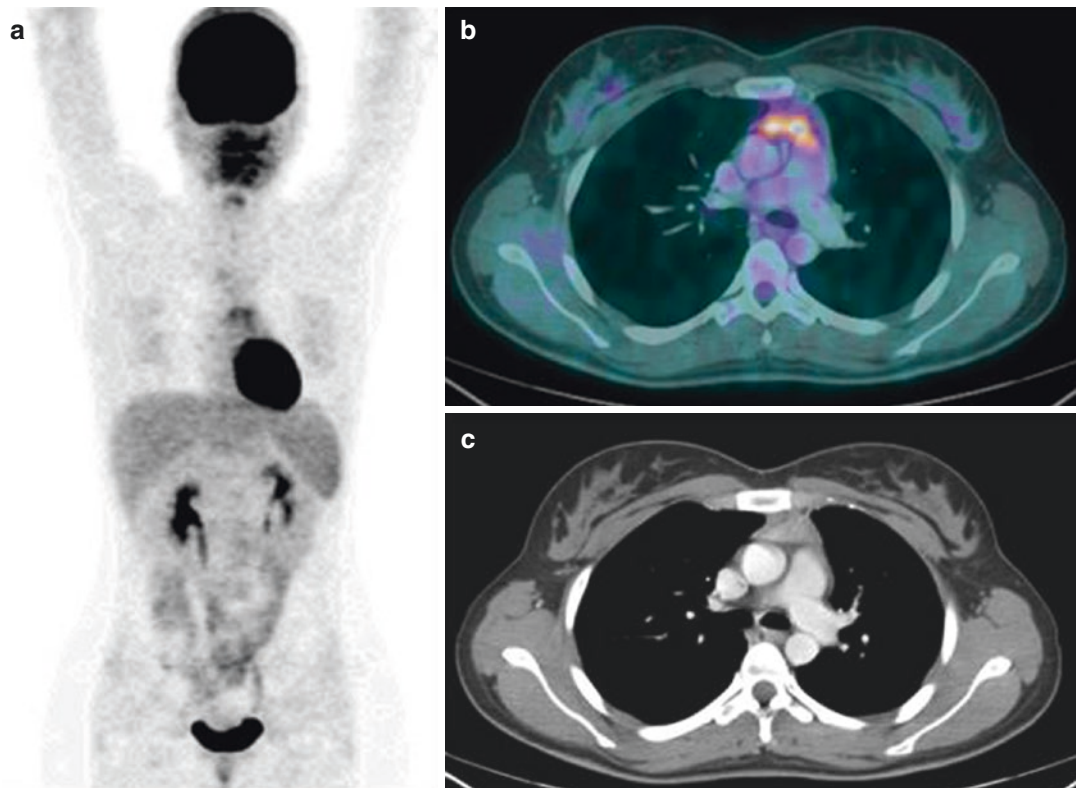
A case of thymic hyperplasia after chemotherapy. ^{18}F -FDG PET 3D whole body maximum intensity projection (a) of a young female patient following chemotherapy for inguinal non-Hodgkin lymphoma, showing
